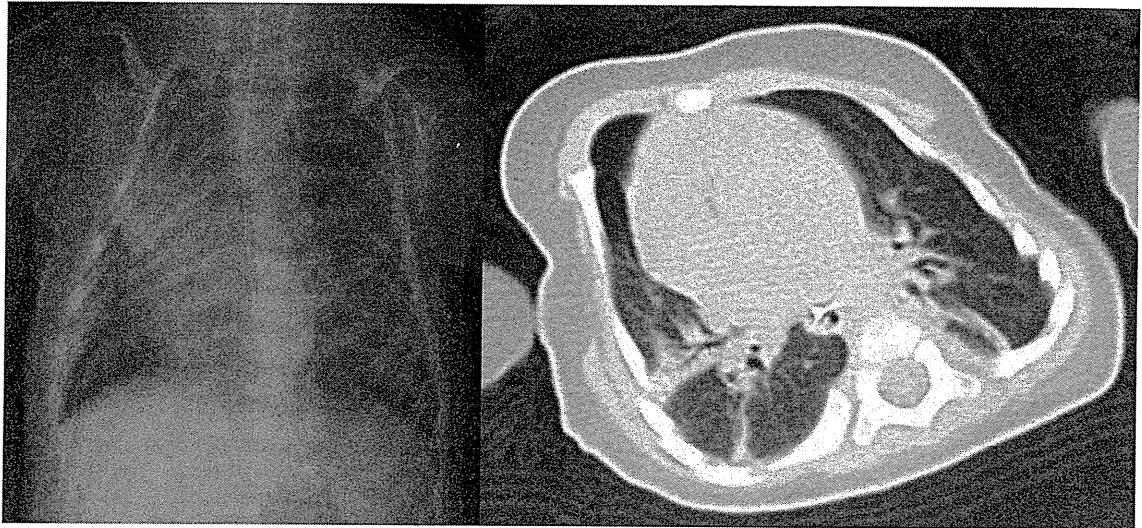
胸部 X 線 (正面像) と胸部 CT (肺野条件)
